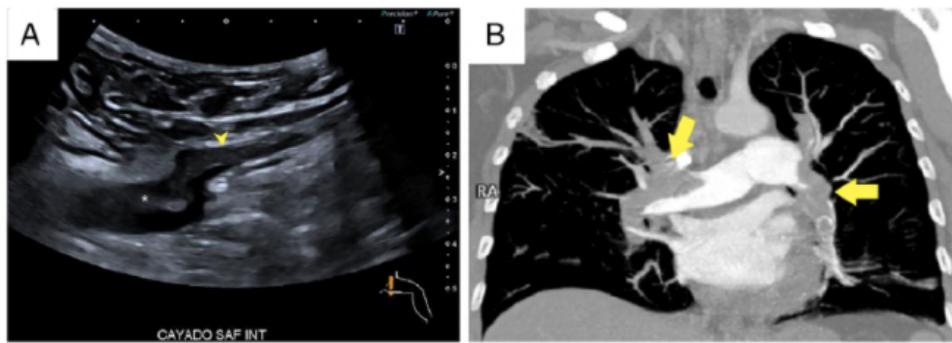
A, Thrombus in the common femoral vein (CFV). Transverse ultrasound scan shows a partial filling defect in the saphenous vein(arrowhead) and the common femoral vein (asterisk) just above the saphenous junction. B, Bilateral pulmonary embolism. Coronalmaximum-intensity projection CT pulmonary angiography shows bilateral filling defects in the two main pulmonary arteries and their lobarbranches (arrows).
